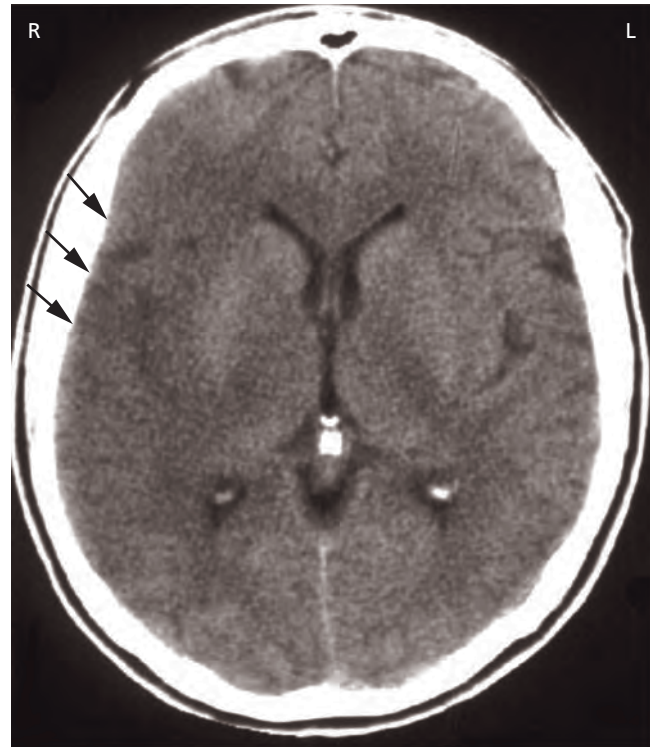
Early partial right hemisphere infarction following MCA occlusion. There is effacement of right temporal sulci, obliteration of the Sylvian fissure, with slight hypo-attenuation of the cortex, right temporal lobe and of the insula (unenhanced CT).
